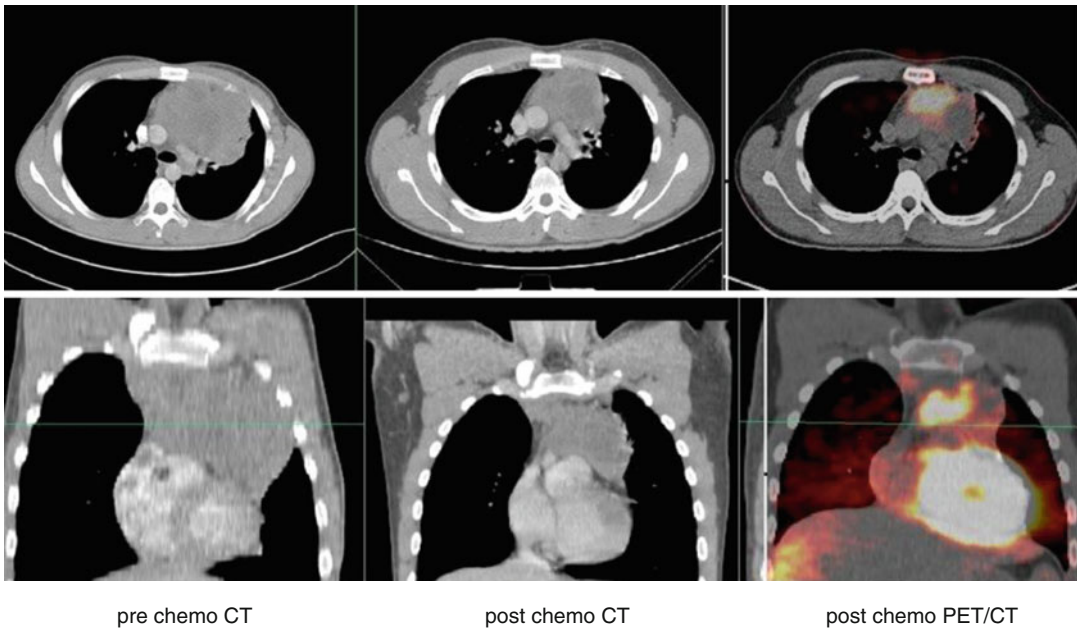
Pre chemo CT, post chemo CT, and post chemo PET/CT results
